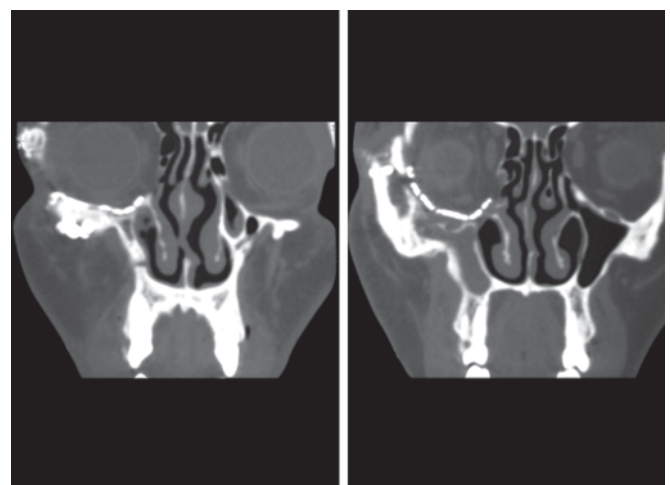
Postoperative CT scan after zygomatic osteotomy
